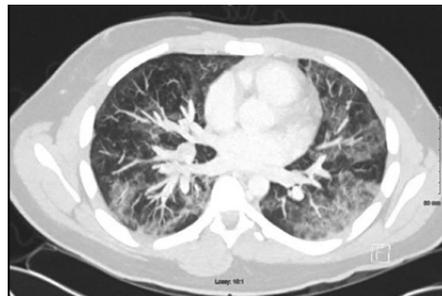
Extensive Interstitial and More Notably Alveolar Ground Glass Opacities in a Patchy Distribution in Both Lungs on Chest CT
